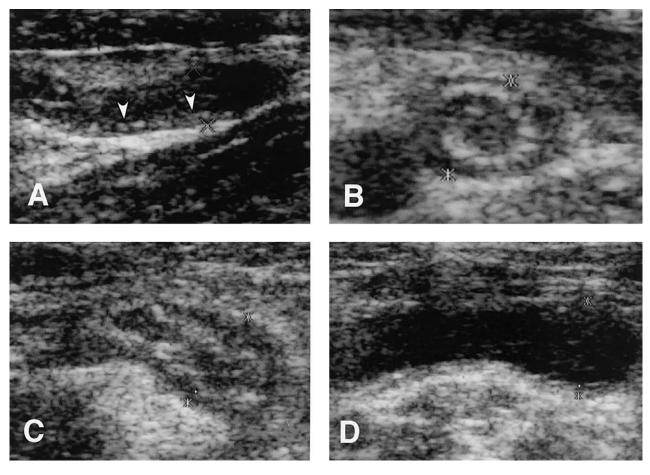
Representative ultrasound images for each grade of appendicitis. (A) Grade I; (B) grade II; (C) grade III; (D) grade IV. The arrowheads indicate the inner echogenic layer.
